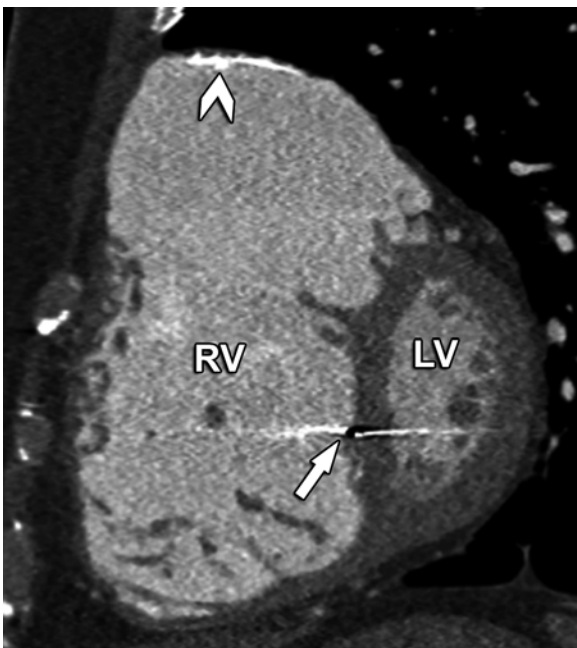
This 30-year-old patient with repaired tetralogy of Fallot had severe pulmonary insufficiency and right ventricular enlargement. The scan was reconstructed in the short axis view from a functional CT scan. Note the transvenous pacer lead beam hardening artifact (arrow) and the calcified transannular patch (arrowhead). The patient underwent right ventricular outflow tract conduit placement. LV left ventricle, RV right ventricle
